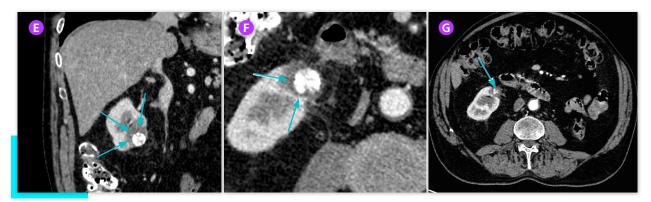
CT (axial plane) shows an
